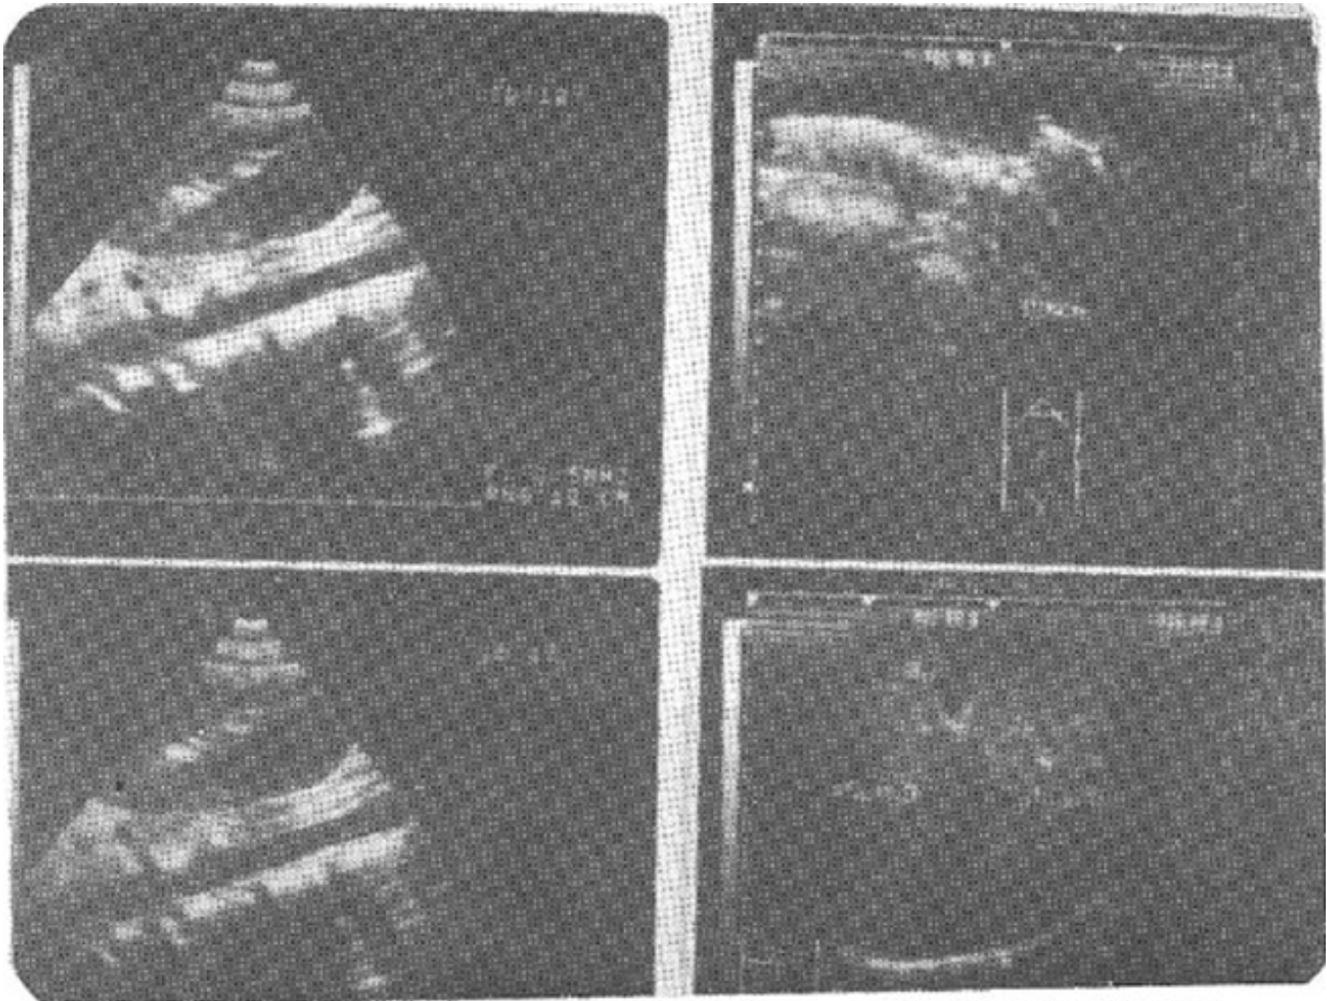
Ultrasound images of stomach and liver. The upper two and lower left show stomach with thickened wall, infiltration and narrowing of lumen, lower right shows liver with normal echogenicity.
